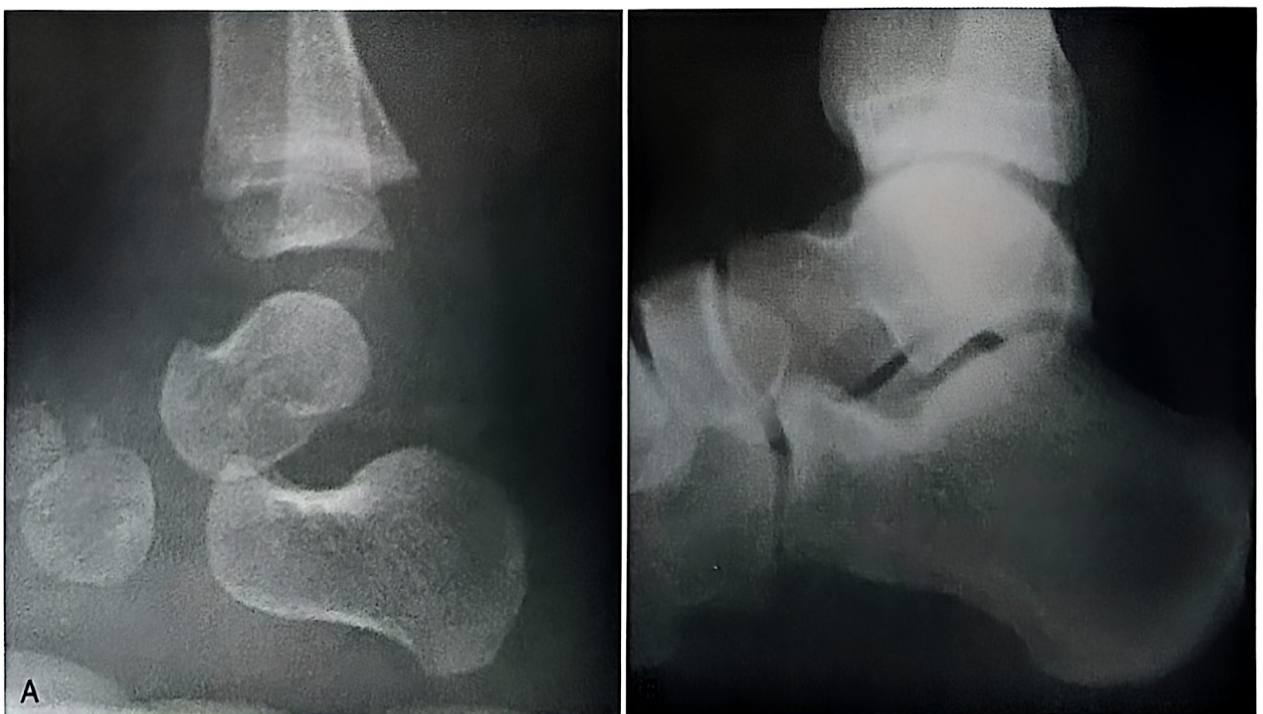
Ankle radiographs show anatomic changes that occur with skeletal maturation. (A) Three-year-old child. (B) Adult.
